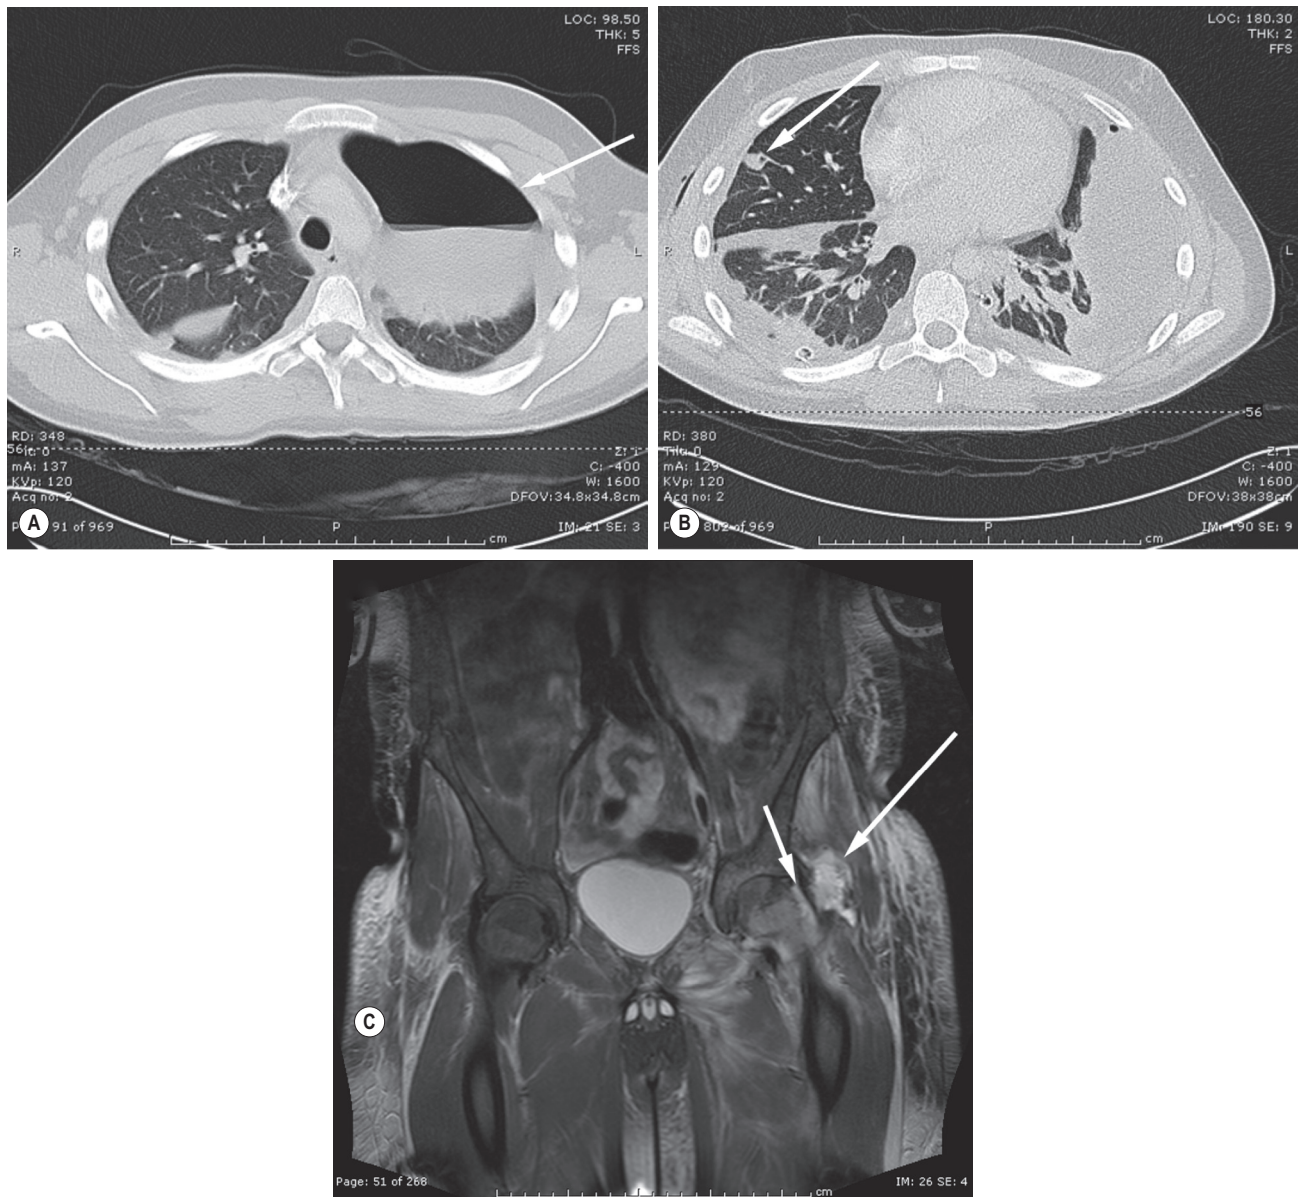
(A) Chest computed tomography scan of a 16-year-old patient with Lemierre syndrome with marked pulmonary involvement shows a large, left-sided pneumothorax (arrow) and adjacent emphysema. (B) Chest computed tomography scan of the same patient shows widespread bilateral pulmonary consolidation and nodular foci. The central cavitation in the lesion is marked by an arrow. (C) Coronal magnetic resonance image shows the hip region in the same patient, who also developed septic arthritis of the left hip joint and abscess formation in the adjacent muscles. Notice the synovial enhancement (small arrow) and the fluid collection (large arrow), which extended anteriorly between the iliopsoas, the rectus femoris medially, and the gluteus muscles laterally.
